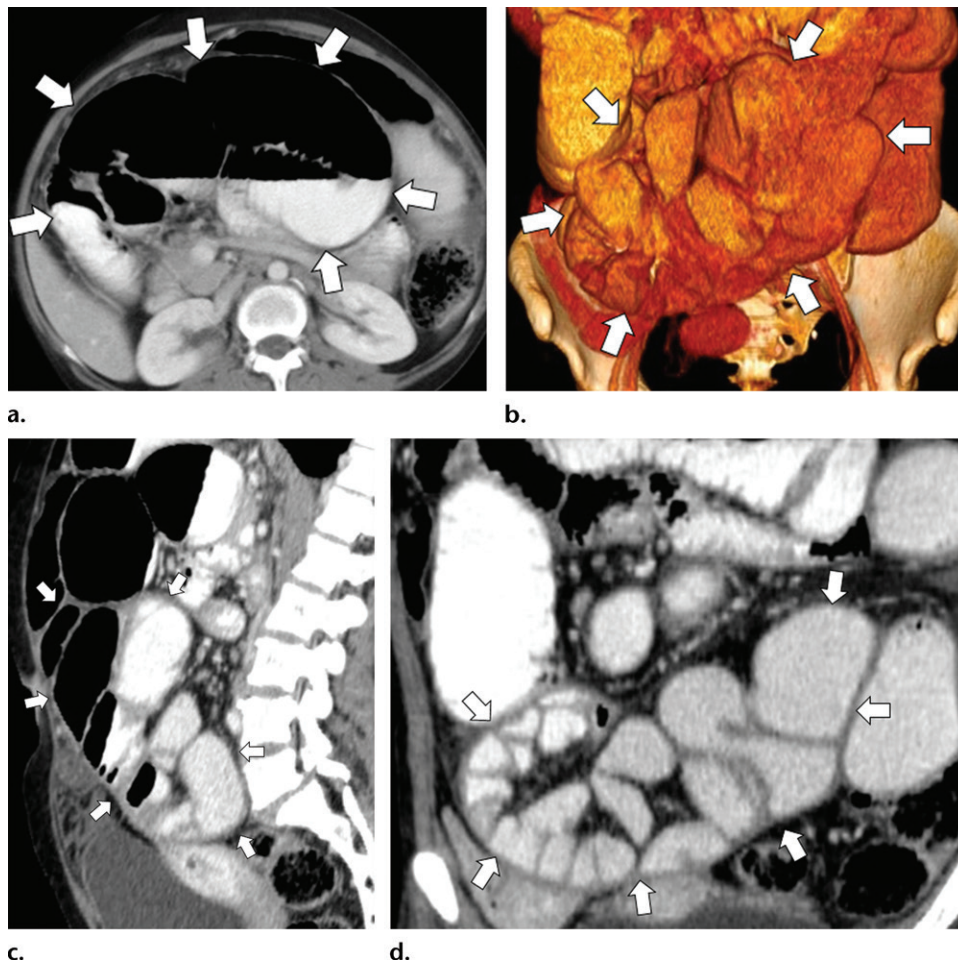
EPS in a 35-year-old woman with bowel obstruction. (a) Axial CT image shows dilated bowel loops with fluid levels in keeping with obstruction (arrows). (b) Volume-rendered three-dimensional CT image in the anteroposterior orientation better shows the clumped pattern of the bowel loops (arrows). (c) Sagittal reformatted CT image better shows the thickened peritoneal membrane enveloping the bowel loops, resulting in small-bowel obstruction with dilated bowel loops (arrows) and fluid levels. (d) Coronal reformatted CT image also shows the thickened peritoneal membrane enveloping the bowel loops, resulting in small-bowel obstruction with dilated bowel loops (arrows) and fluid levels.
